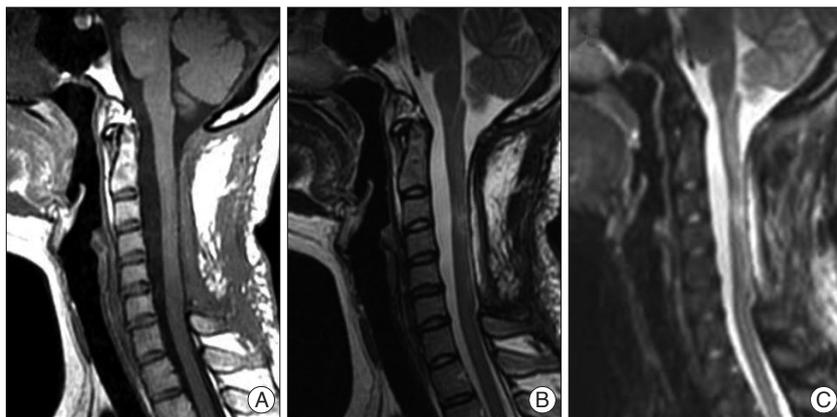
Postoperative cervical MRI (after 3 months from surgery) shows improvement of cord swelling and remaining focal high signal foci on T2 weighted image. A : T1 weighted image. B : T2 weighted image. C : T1 weighted enhanced image.
